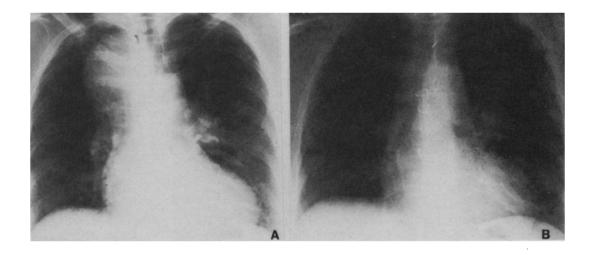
Case 1. Chest roentgenograms before (A) and 3 years after (B) repair of the aneurysm. Note decrease in width of superior mediastinum.
